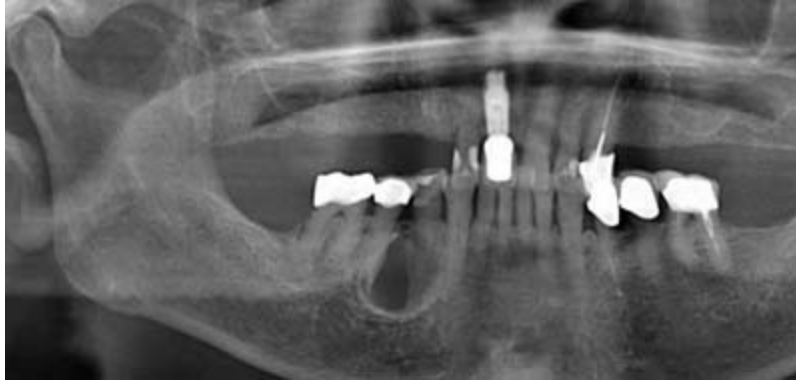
Although most odontogenic keratocysts occur as multilocular radiolucencies at the angle of the mandible, they can be located at any position in either jaw. A cropped panoramic radiograph reveals a corticated odontogenic keratocyst in the mandibular right premolar region.
